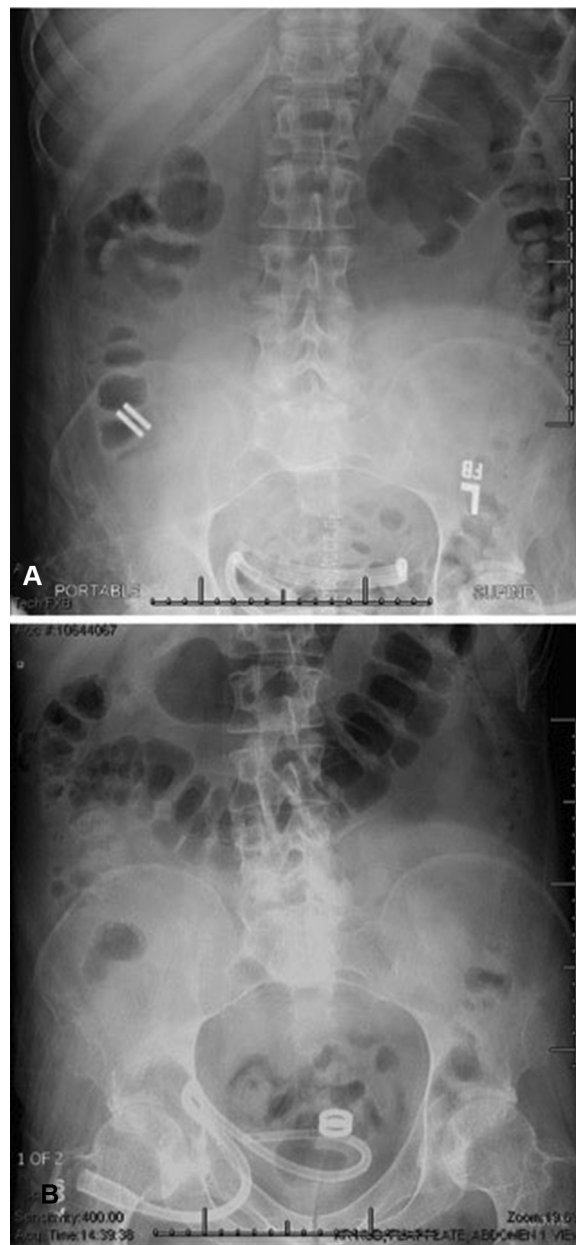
Magnet passage. Mated magnets are visible on abdominal x-ray. (A) First in the right lower quadrant soon after placement, and (B) in the superior rectum 1 day before passage.
